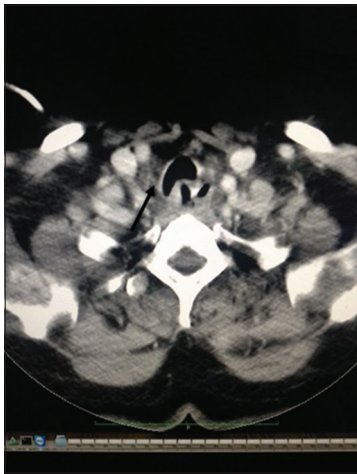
Computed tomography scan neck and chest showing the tracheoesophageal fistula tract
